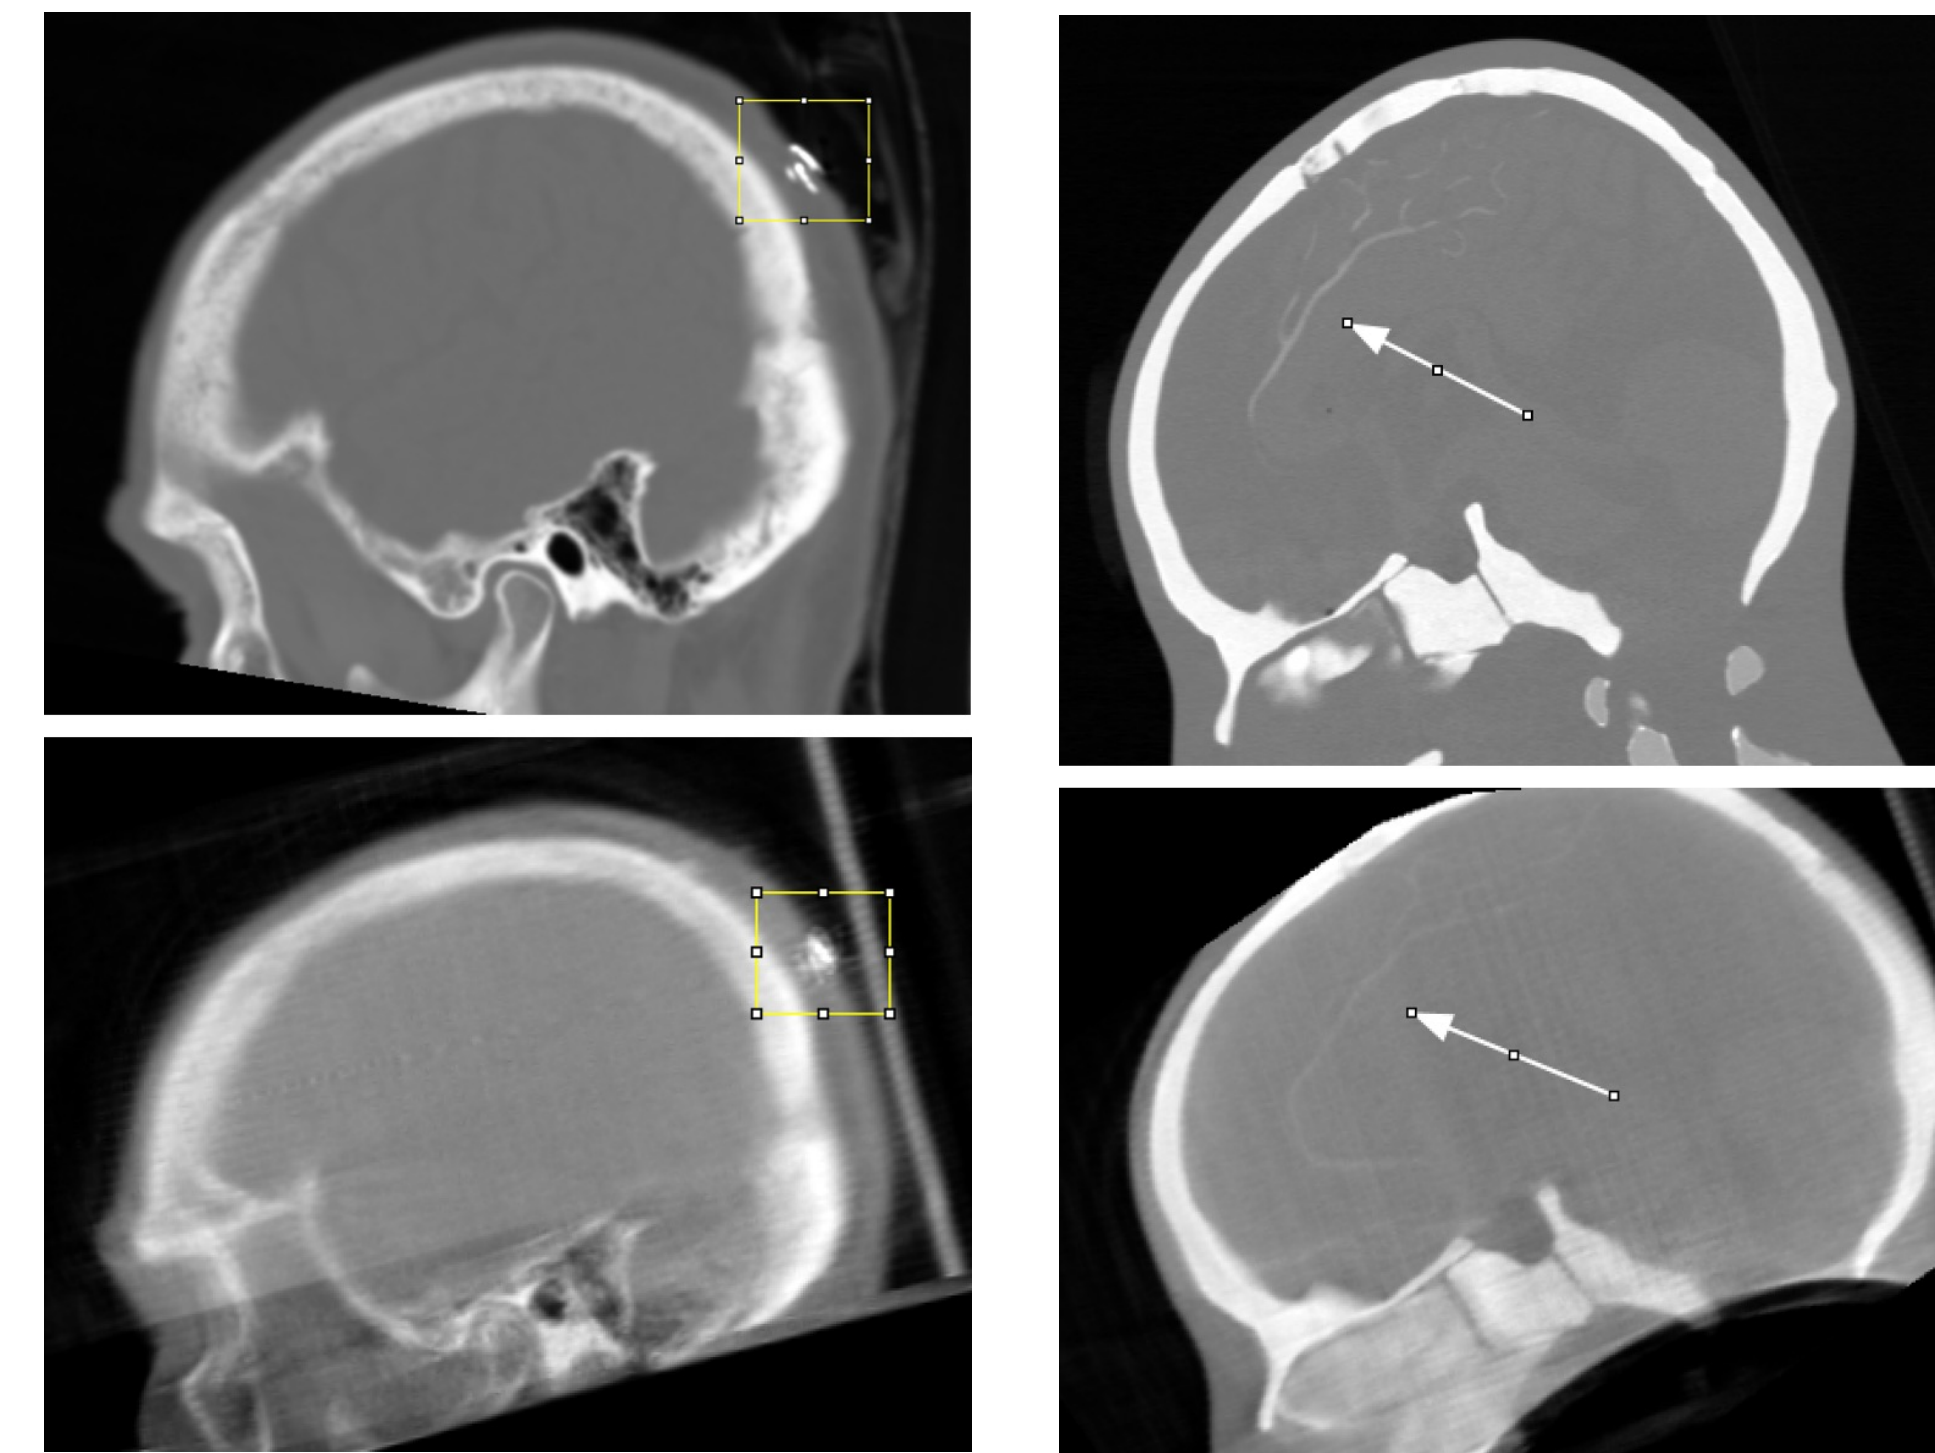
Metal staples presented in sagittal slice of both the SIEMENS clinical head CT (top) and the CNT s-HCT prototype (bottom) of Subject 1
